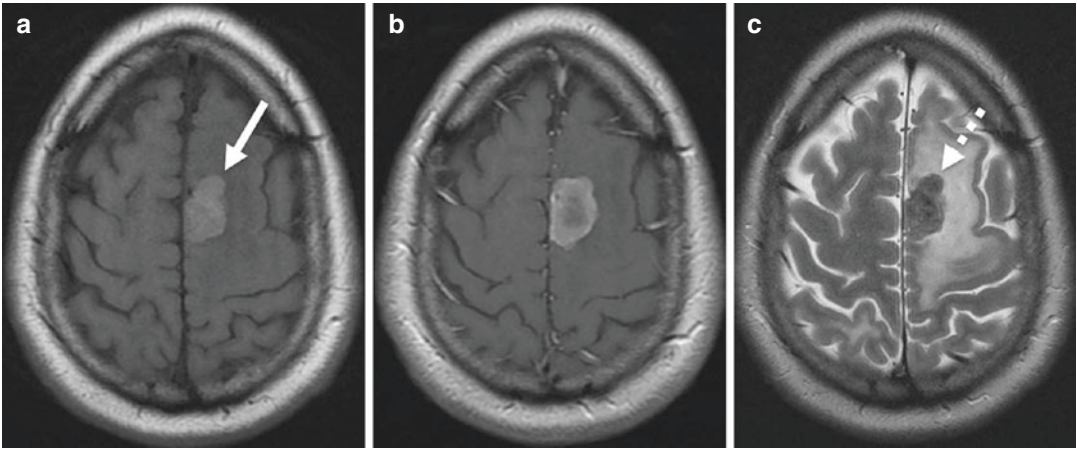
Melanoma metastasis. (a) Pre-contrast T1-weighted image demonstrates intrinsic hyperintense signal due to melanin (arrow). (b) Post-contrast T1-weighted image demonstrates accompanying avid
